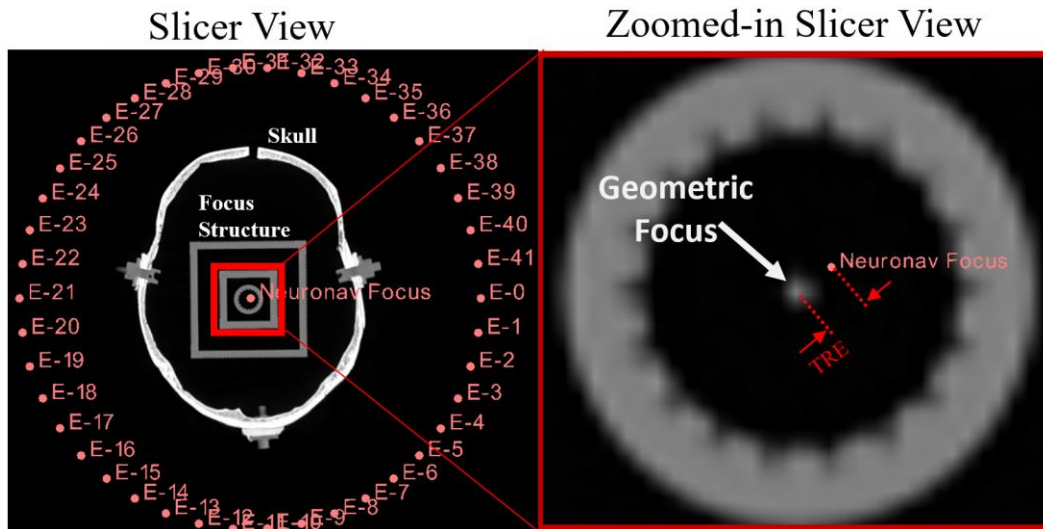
Calculating the TRE. The Kranion scene, which includes the skull and focus structure CT, transducer element locations, and the transducer focus (i.e. neuronavigation focus), is exported into Slicer, and the TRE is calculated from the focus structure central point, (i.e. geometric focus or the true target) to the ‘neuronavigation focus’.
